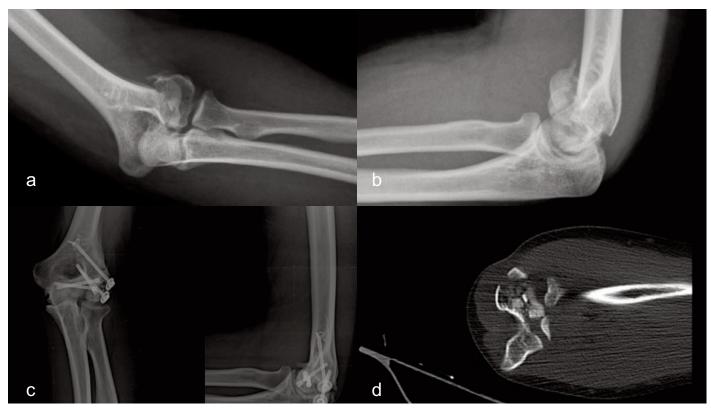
a) Preoperative radiography of elbow joint. b) Preoperative lateral radiography of elbow joint. c) Postoperative anteriorposterior radiography of elbow joint. d) Preoperative computerized tomography of elbow joint.
